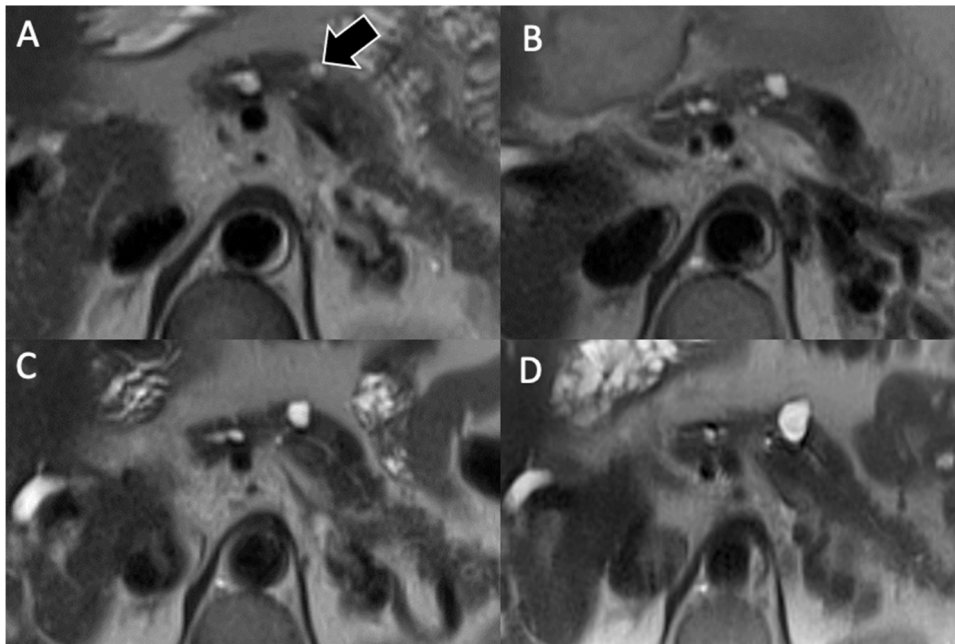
61-year-old man with IPMN increasing in size after 8 year stability. T2-weighted non-fat sat sequence acquired in 2010 (A), 2015 (B), 2018 (C) and 2020 (D), show a BD-IPMN (arrow) with a maximum diameter of 7 mm, 8 mm, 10 mm and 16 mm, respectively.
